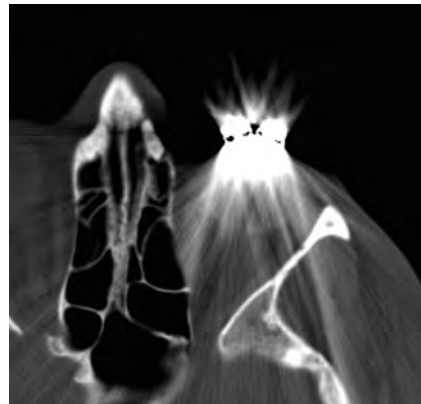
Eyelid weight. Axial CT image shows extensive streak artifacts related to the left eyelid weight, which obscures surrounding structures.
